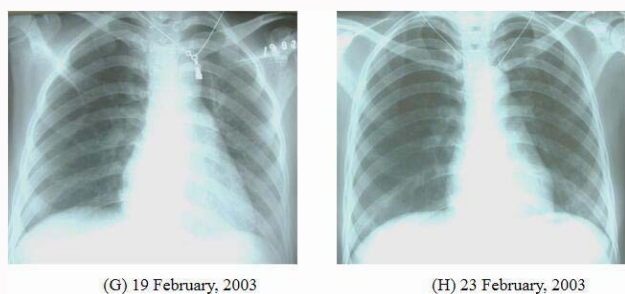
The recovery of pulmonary lesions. G) The majority of bilateral pulmonary lesions disappeared. H) The lungs returned to normal on chest X-ray.
